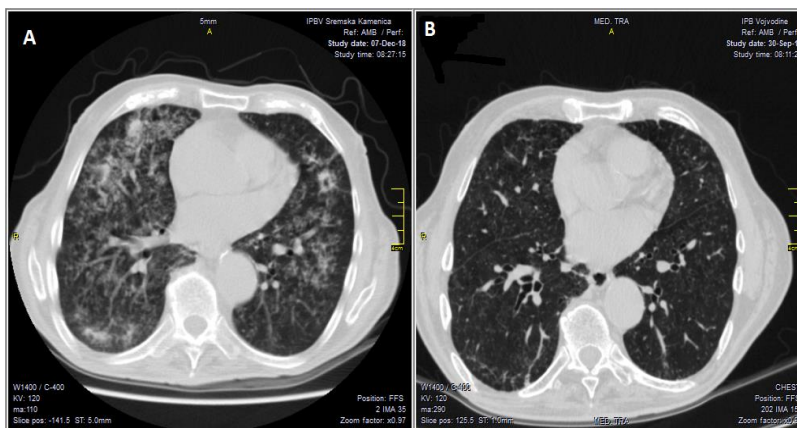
CT scans before (A) and after treatment (B)
